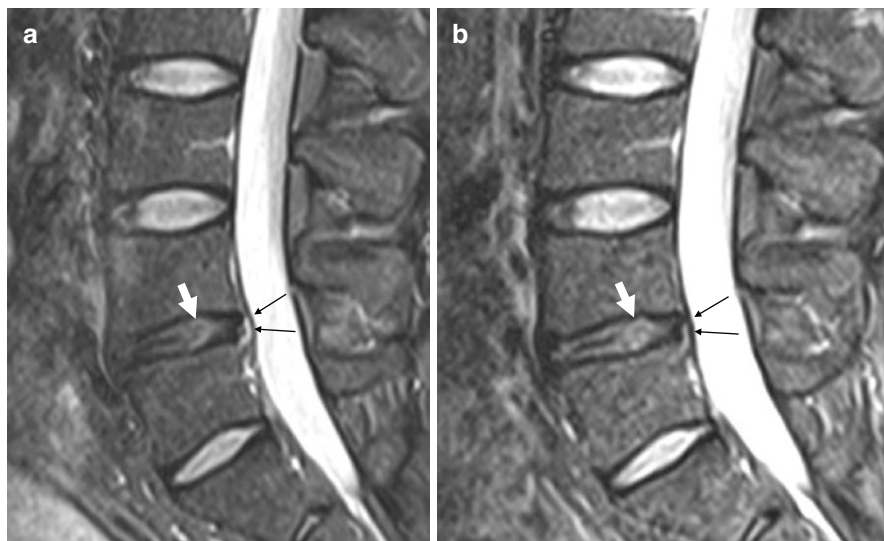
Lateral STIR MR images of the lumbar spine from the same patient taken at baseline (a) and 6 months following injection of ViaDisc (b) showing less posterior prominence of the intervertebral disc at the 6 month time point (black arrows) and increased signal within the nucleus pulposus (white arrowhead). The subject's VAS and ODI decreased from 58 and 50 to 0 and 0 respectively at 6 months
